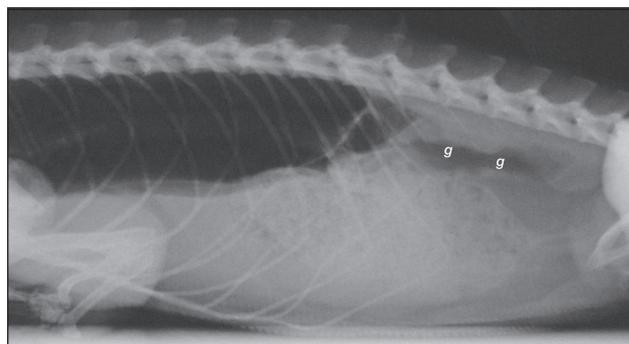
Horizontal abdominal radiograph of a green iguana (*Iguana iguana*) with gas accumulation (g) ventrocranial to the kidneys. The gas cavity appeared more dorsal than in the lateral abdominal radiograph (see Figure 1).
